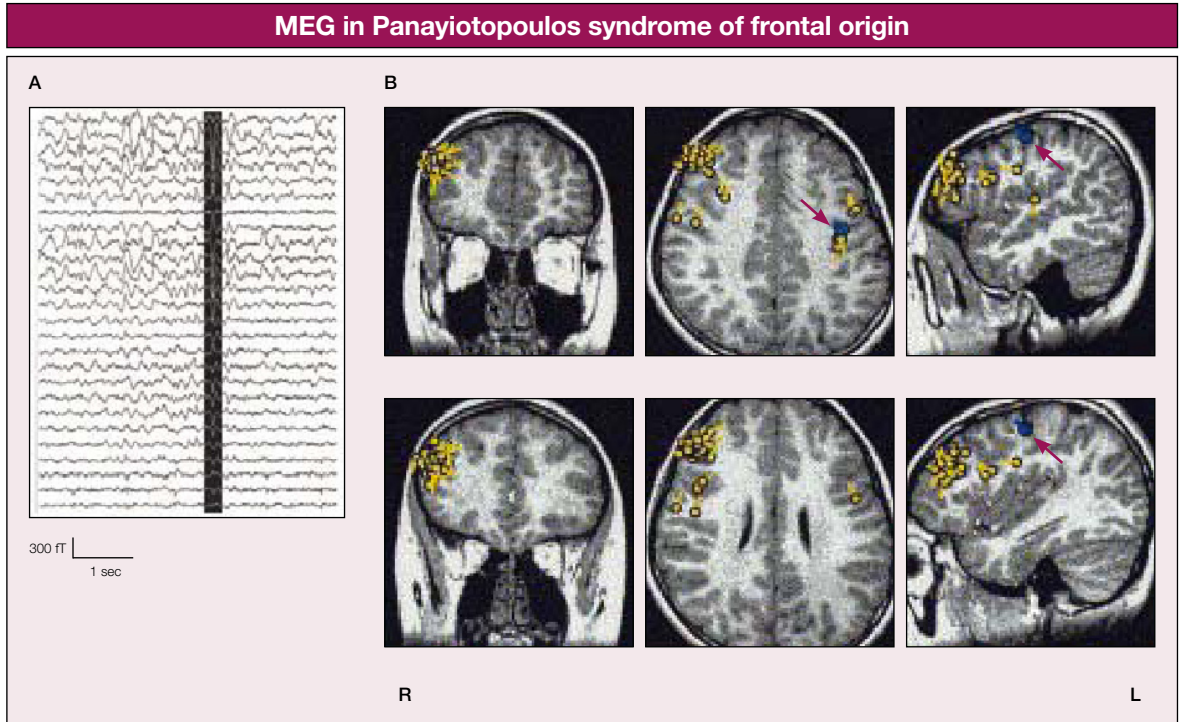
The patient had seizures typical of PS from the age of 4 years. EEGs initially showed occipital spikes, but at age 13 the EEG had bifrontal spikes and MEG was performed. His younger brother also had PS preceded by febrile seizures and followed by rolandic seizures. (A) MEG wave forms. The reversed coloured MEG wave forms in white in the vertical dark zone were analysed. (B) Magnetic source images revealed clustering equivalent current dipoles of spike discharges alongside the right inferior frontal sulcus, but the orientations were not so regular. All MRIs are T1-weighted. The pale-coloured solid circles and tails represent the locations and orientations of equivalent current dipoles of the spike discharges. The early somatosensory evoked field was modelled using a single equivalent current dipole approach to estimate the spatial source of response, whereas the dark-coloured solid circles and tails indicated by red arrows represent the locations and orientations of somatosensory evoked fields (N20).
